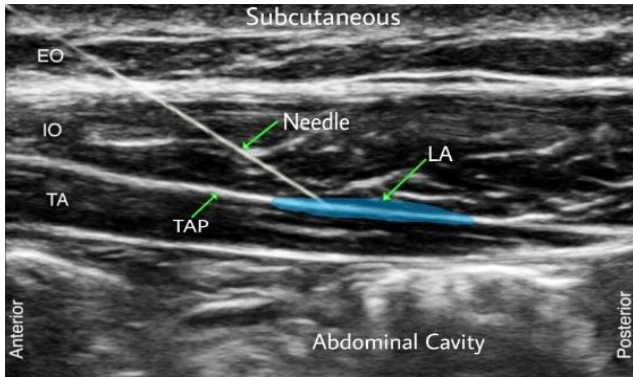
Ultrasound visualization from anterior to posterior on transverse orientation for Lateral TAP block with needle insertion in-plan: TA=Transversus abdominis muscle, IO=Internal oblique muscle, EO=External oblique muscle, LA= Local anesthesia spread (blue), TAP= Transversus Abdominis Plane.
